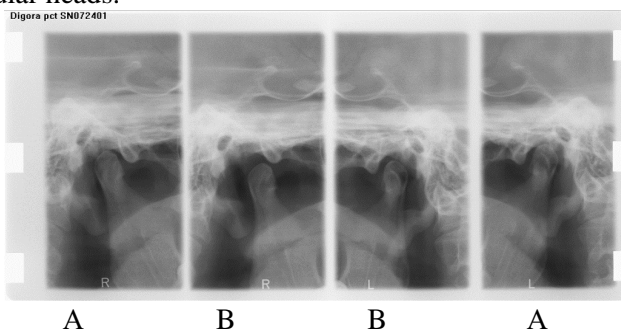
Targeted X-ray of the TMJ with closed (A) and open (B) mouth of the patient with muscular contractures closed.
